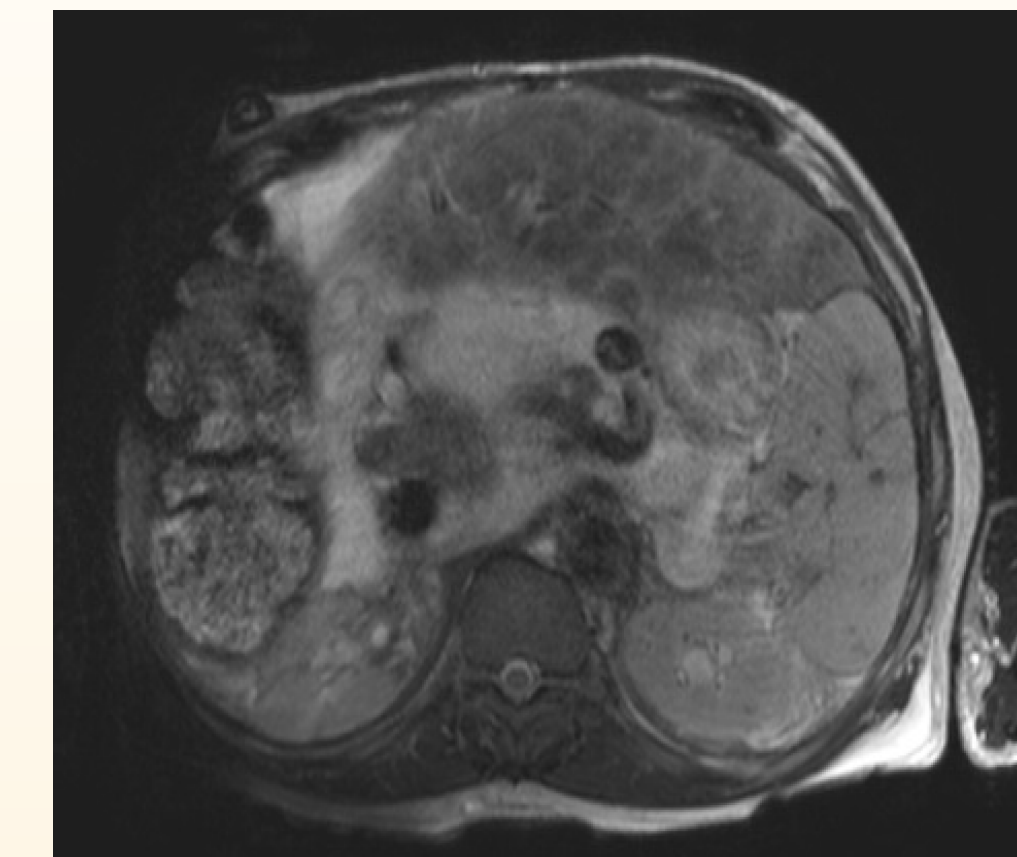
Abdominal MRI showing severe hepatic cirrhosis, likely complicated by loculated ascites
